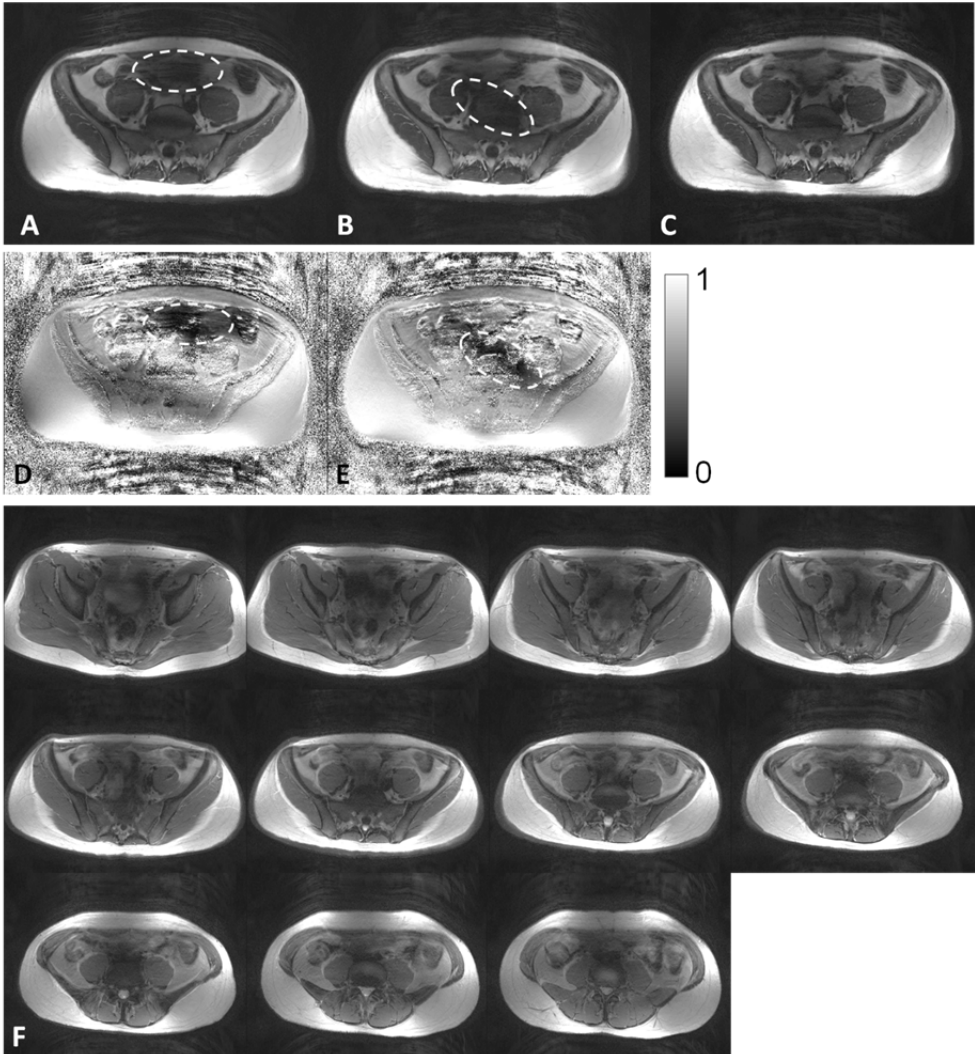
Pelvic T2-weighted TSE images of a human volunteer with a non-interpolated resolution of $0.68 \times 0.68 \times 4 \text{ mm}^3$ acquired with A) the CP^+ mode and B) the CP^{2+} mode (both GRAPPA $R = 2$). The differing location of the most significant signal dropout, where the signal and therefore the SNR drop to 0, is marked. C) TIAMO reconstructed image with the interleaved acquisition of the CP^+ and CP^{2+} modes took only 14% more acquisition time (GRAPPA $R = 4$) than an individual mode; no complete signal dropout is visible. D) and E) show the signal
